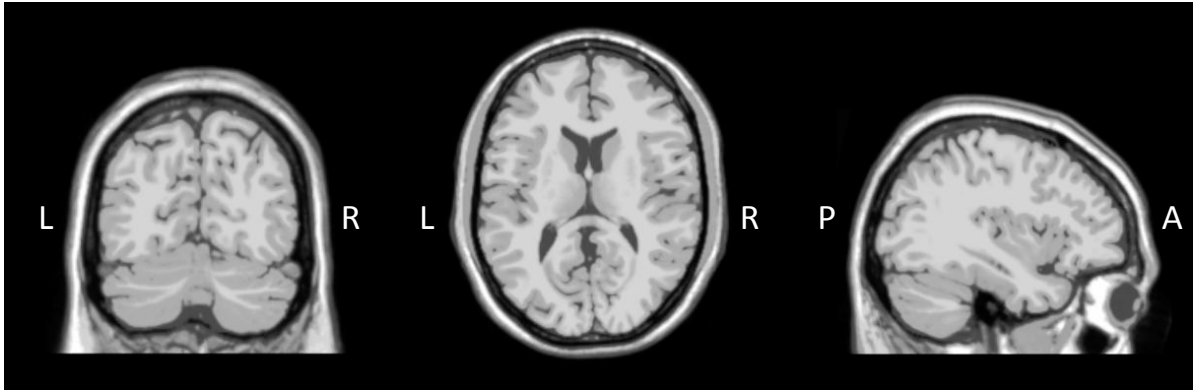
High resolution adult MRI dataset (Colin 27) as used for generating the head model in this study. 27 T_1 -weighted scans and 12 T_2 -proton density-weighted scans are intensity averaged resulting in a single volume with high signal to noise ratio in all 3 dimensions. Abbreviations are: L=left, R=right, P=posterior and A=anterior.
